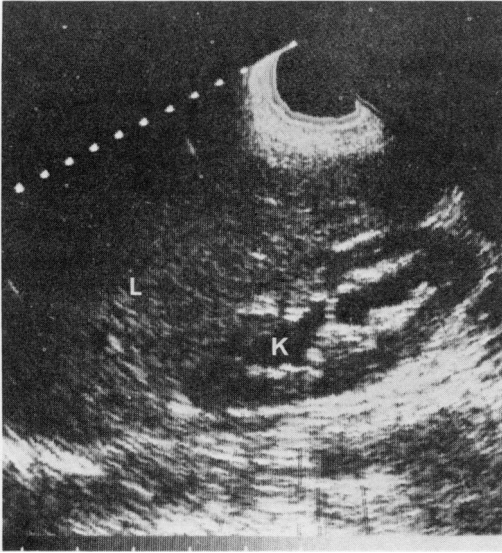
Ultrasound examination of the right upper abdomen [liver (L), kidney (K)] shows centrally located large echo-free areas in the right kidney characteristic of a dilated collecting system.
